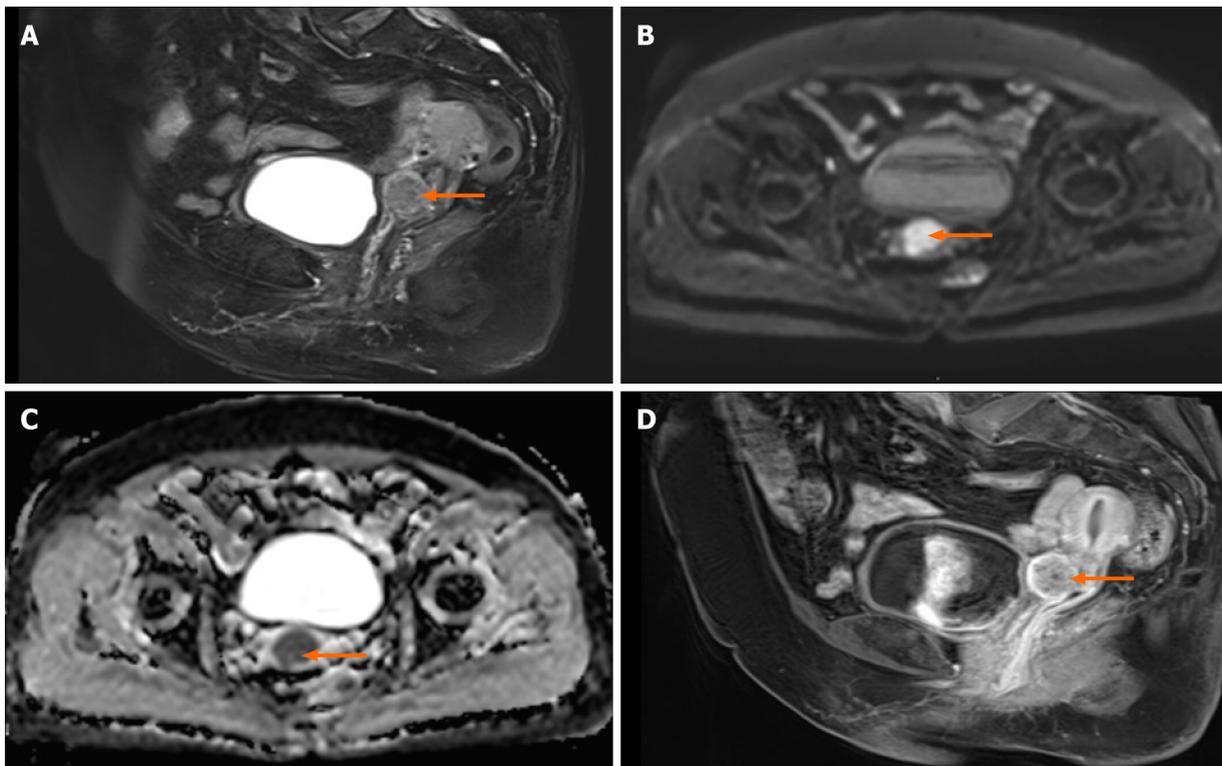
Pelvic enhanced magnetic resonance imaging images. A: The anterior lip of the cervix showed a slightly high signal on T2WI, with a diameter of about 2.5 cm; B: DWI diffusion was limited and showed high signal; C: Apparent diffusion coefficient value decreased, which was $0.838 \times 10^{-3} \text{ mm}^2/\text{s}$; D: On contrast-enhanced scan, slight enhancement was observed in the edge. Orange arrows indicate cervical lesions.
